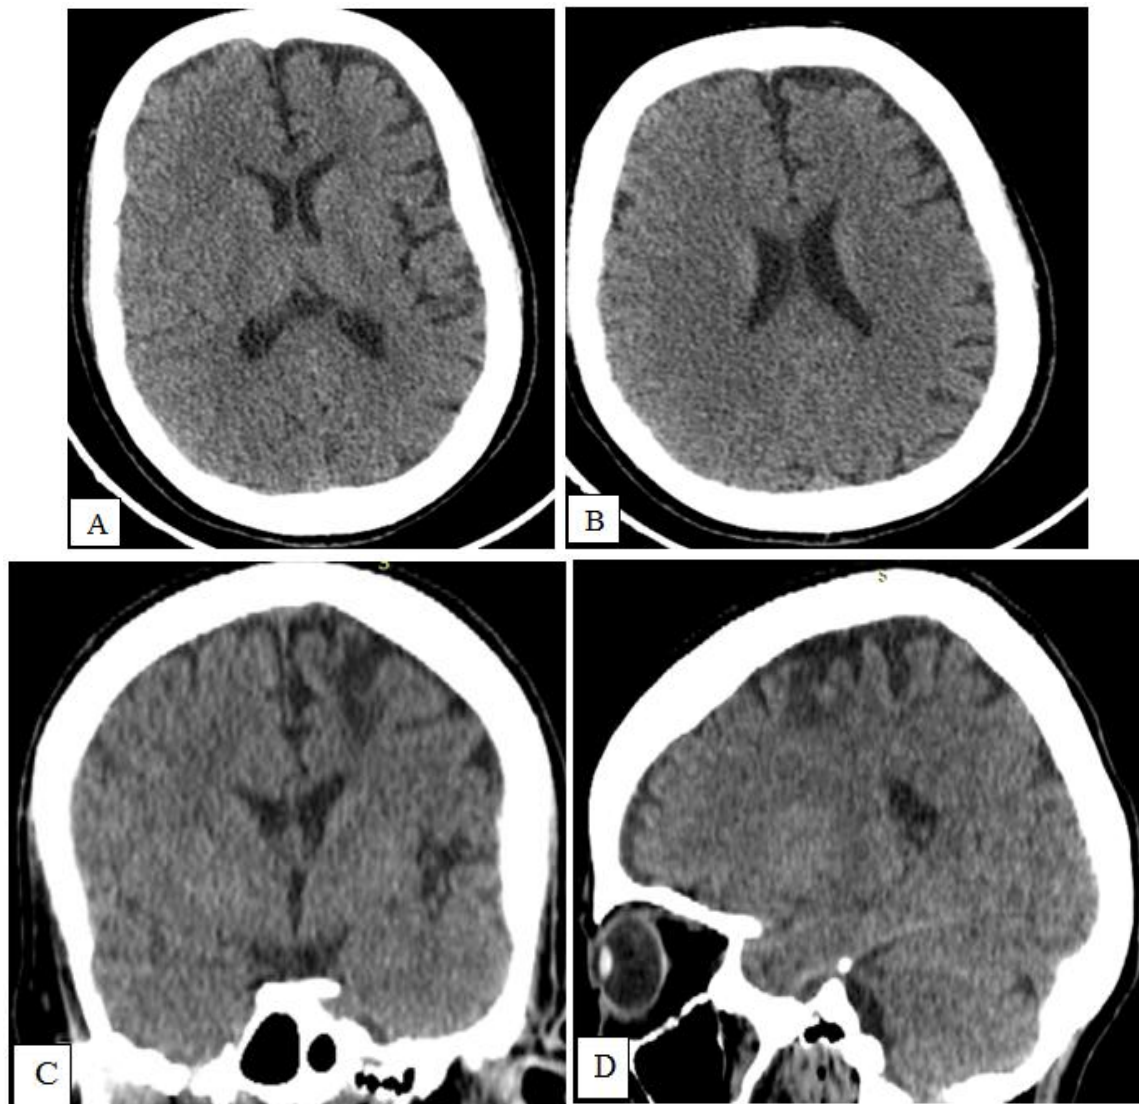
Axial (A and B), coronal (C) and sagittal (D) Brain CT showing a left cortical hemiatrophy with a subcortical non enhancing hypodensity, ill-defined, with a minimal cortical involvement. Adding to that is the discreet dilatation of the ipsilateral ventricle
